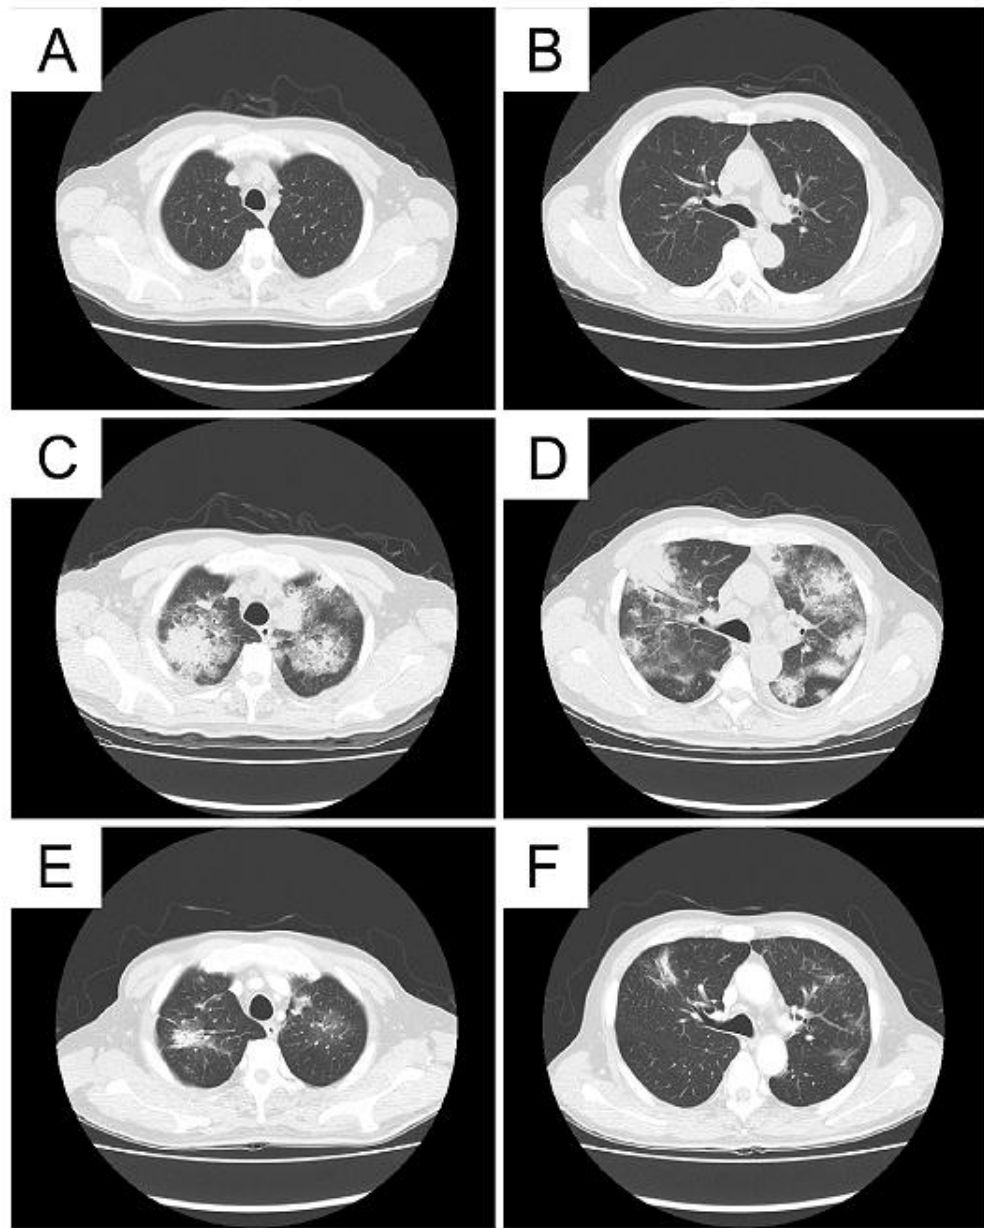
CT-Scan, with contrast agent, on admission (left side) and high-resolution computer tomography during treatment (right side).
